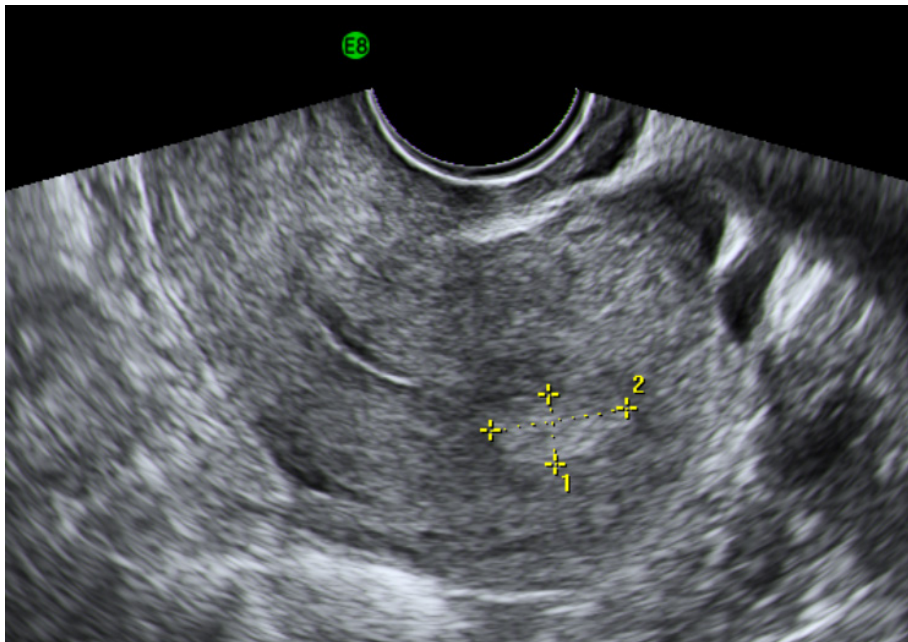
Transvaginal ultrasound showing an endometrial polyp
